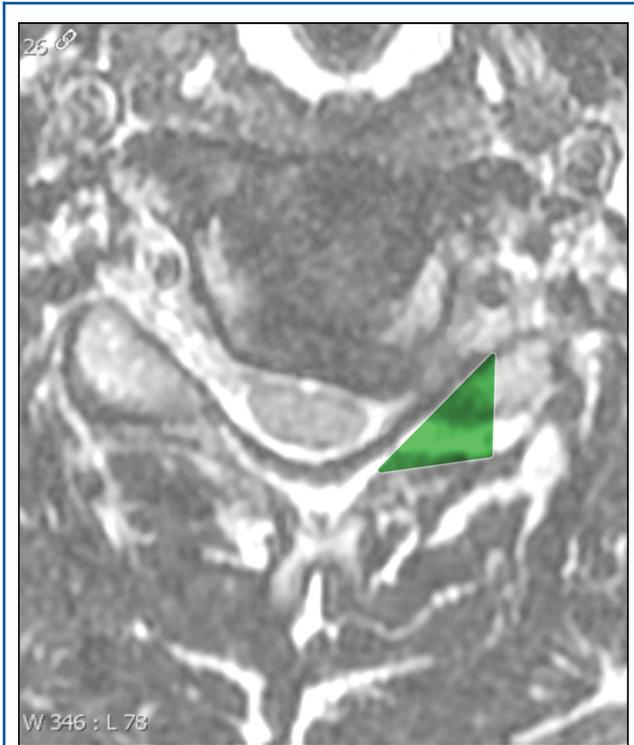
Preoperative MRI showing left C6 foraminal stenosis. The extent of intended decompression is marked by the green triangle, requiring approximately half of the facet be removed.
